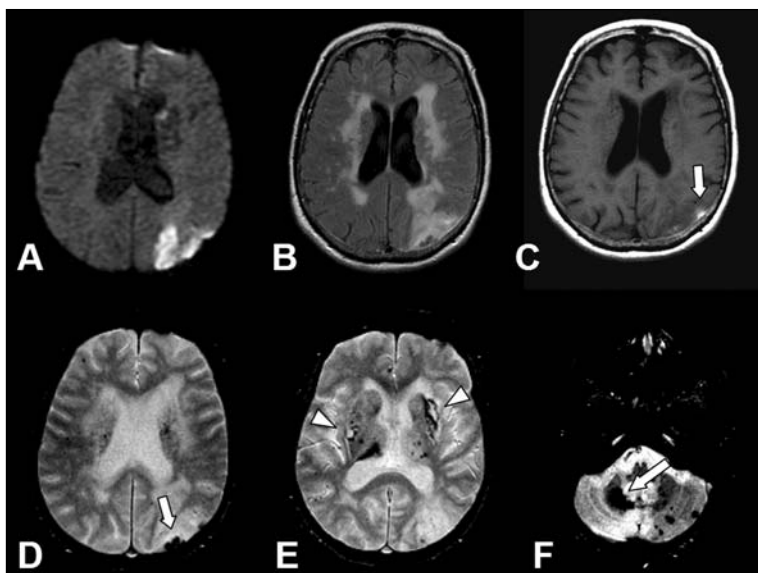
Axial diffusion-weighted image (A) discloses the left acute occipitoparietal infarct. Axial FLAIR image (B) demonstrates increased signal in the acute infarct area and also confluent areas in the cerebral white matter bilaterally, suggestive of small vessel ischemic disease. Axial T1-weighted image (C) presents foci of high signal in the area of the acute infarct (arrow), presumably related to the presence of hemorrhage (methemoglobin). Axial T2*-weighted images show clearly other hemorrhagic areas in the acute infarct, with marked hypointensity (arrow in D) and also innumerable punctate foci of marked hypointensity in the basal ganglia (arrowheads in E), thalami and right cerebellar hemisphere (arrow in F), possibly related to previous microbleeds.
